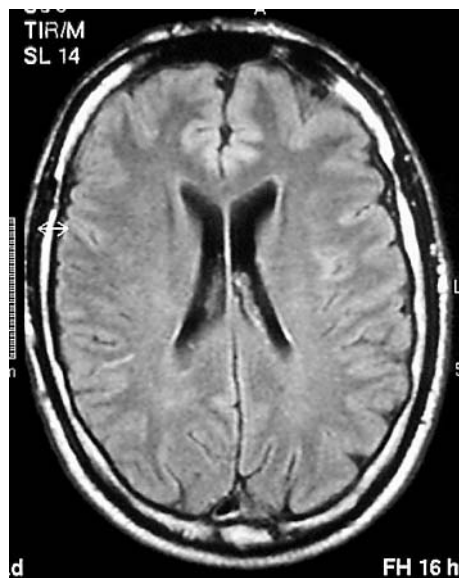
Cranial MRI (axial FLAIR sequence) 3 months after the discectomy which was normal.
